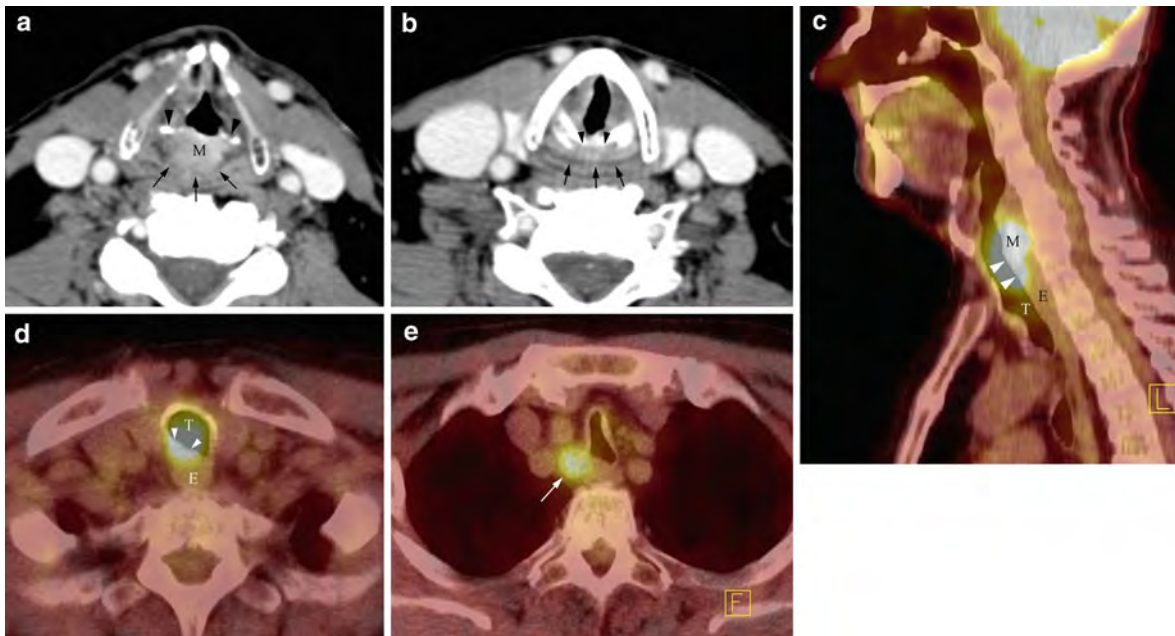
Axial contrast-enhanced CT image at the hypopharynx level (a) reveals a small mass (*M* in a) between the arytenoid cartilages (*arrowheads* in a) that partially infiltrates the anterior submucosal fat plane (*arrows* in a). Slightly more inferiorly, the axial contrast-enhanced CT image (b) shows restoration of the submucosal fat plane (*arrows* in b) suggesting that the tumor is localized to the interarytenoid region (*M* in a). Closer evaluation, however, discovers a large erosion (*arrowheads* in b) of the cricoid cartilage posteriorly. Since this is symmetric in distribution, it can be mistaken for
